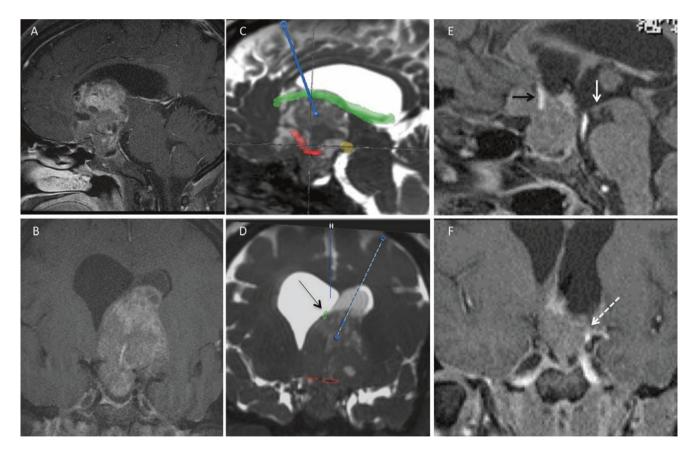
(a–f) Preoperative sagittal (a) and coronal (b) T1 MRI demonstrating large recurrent pituitary adenoma encasing anterior cerebral arteries, extending along planum, invading through the frontal lobe, filling the anterior third ventricle, and extending up to the roof of the left lateral ventricle. (c–d) Preoperative plan demonstrating surgical trajectory (*blue line*) of tubular retractor. Left-side cannulation through smaller ventricle was chosen as this was felt to have less chance of forniceal (*arrow*) injury during tumor resection. *Fornix (green); ante-*
